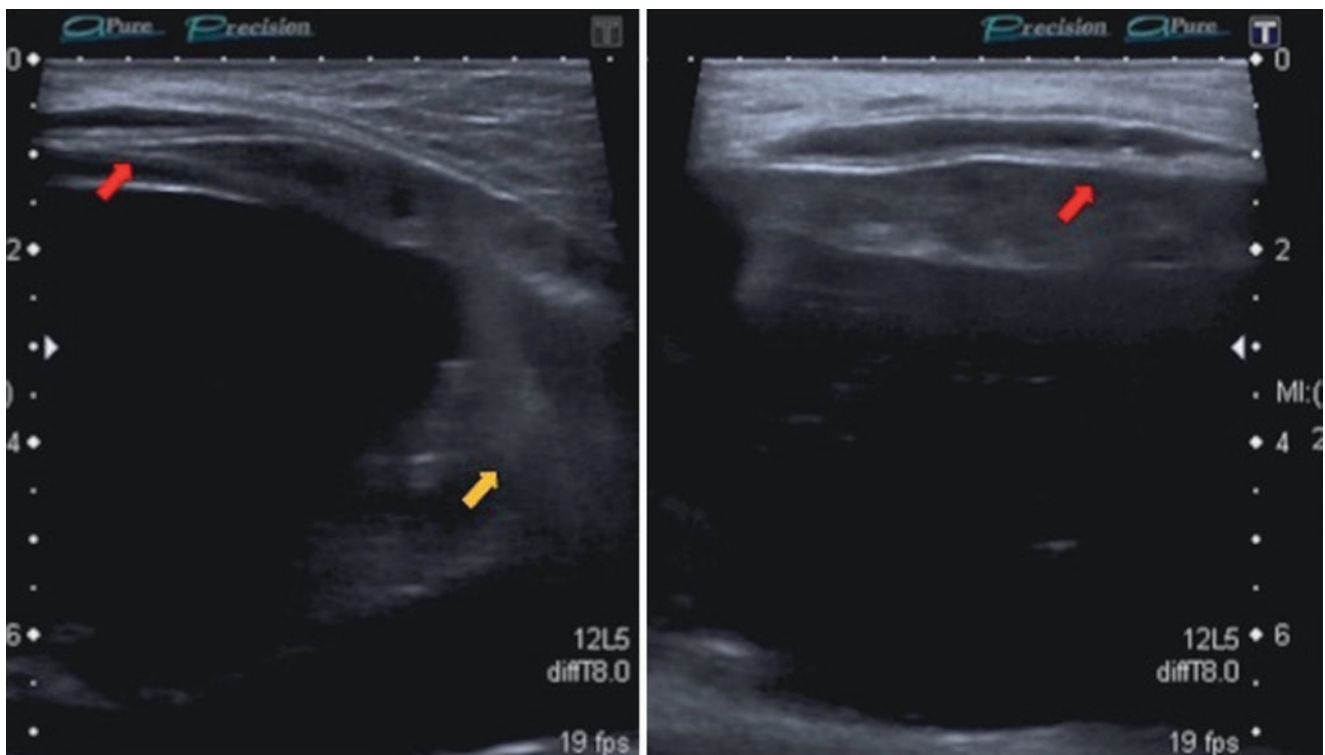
Ultrasound showing an intracapsular rupture: Irregular subcapsular line under the shell (red arrow) and hyperechoic content and lines inside the implant (yellow arrow)
